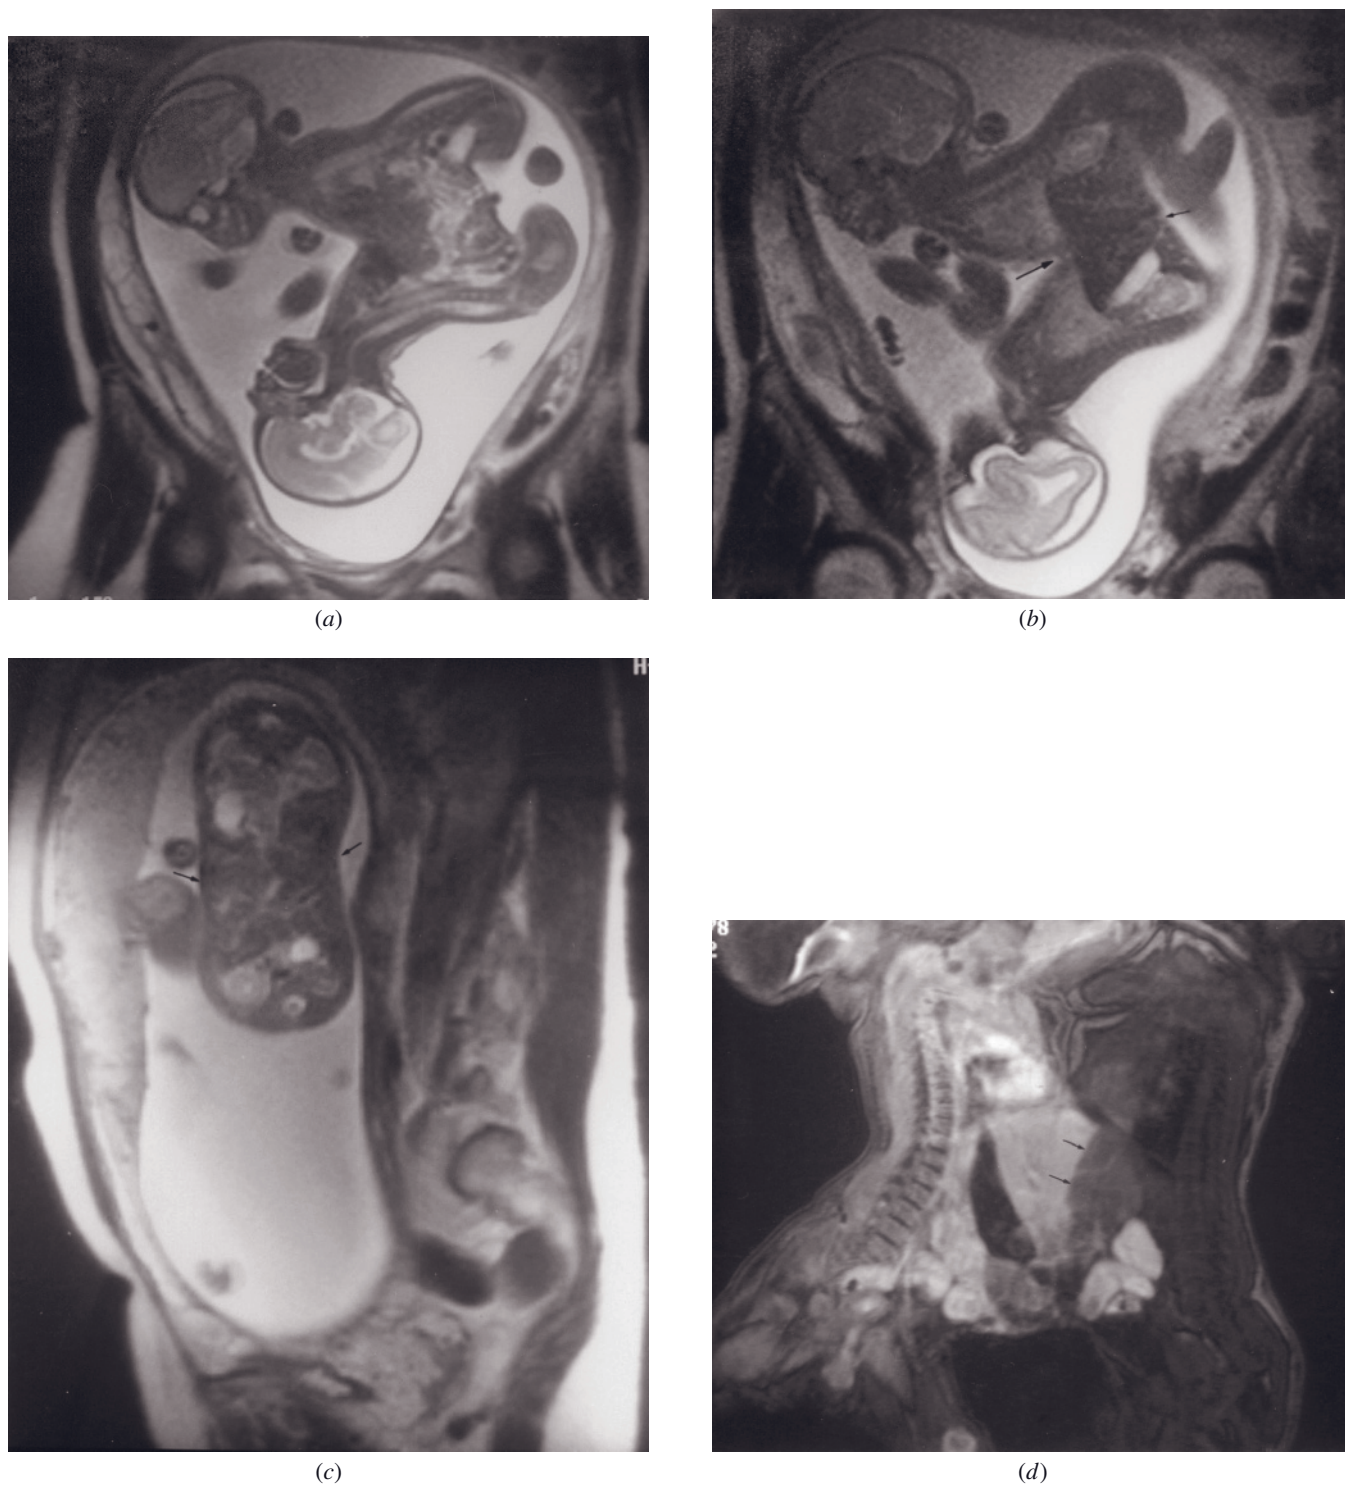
Conjoined twins. Sagittal (*a*, *b*) and axial (*c*) T2-weighted SS-ETSE images demonstrate in utero conjoined twins. The peritoneal cavities of the conjoined twins are in continuity, and the livers are attached (arrows, *b*, *c*). Interstitial-phase gadolinium-enhanced fat-suppressed gradient-echo image (*d*) after gadolinium was administered to 1 neonate 1 day after birth demonstrates sharp demarcation of enhancing and nonenhancing livers (arrows, *d*), signifying that the hepatic vasculature of the twins is separate.
